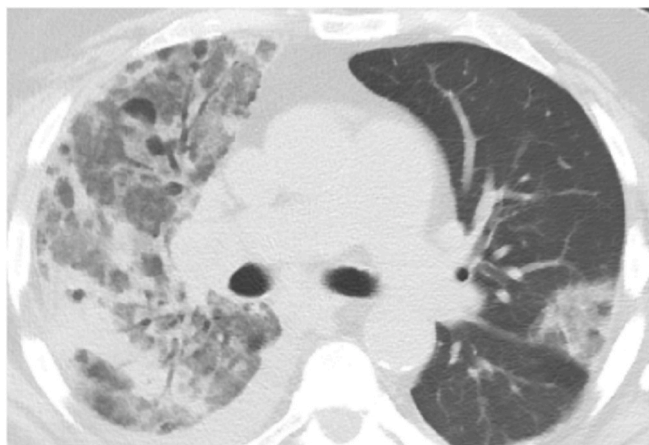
A chest HRCT scan showing multiple bilateral consolidations, mainly on the right side, with subpleural and peribronchial distribution, associated with diffuse patchy bilateral areas of ground glass opacity and right pleural effusion.
